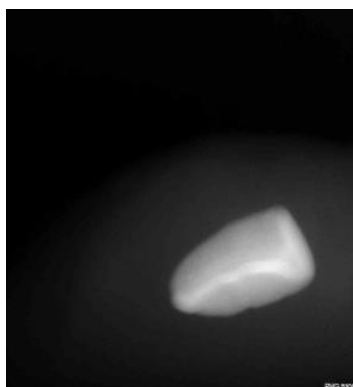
Radiograph of lower lip showing fractured fragment.
